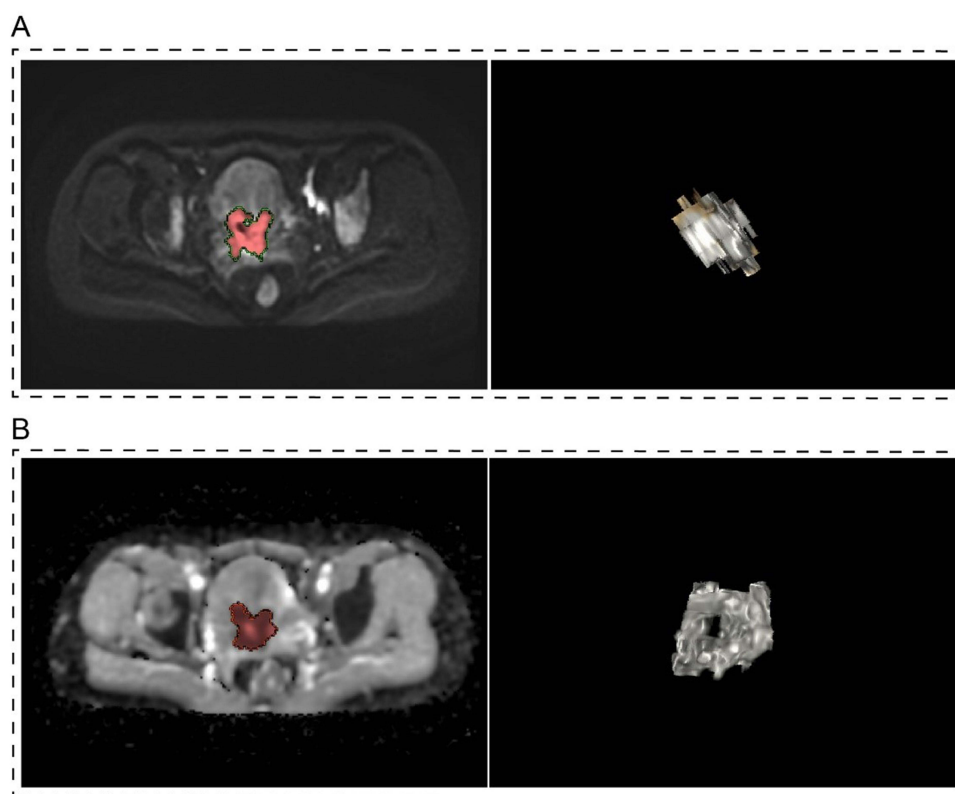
ROIs of MRI segmentation in this study (A). ROIs on T2WI; (B). ROIs on ADC.
